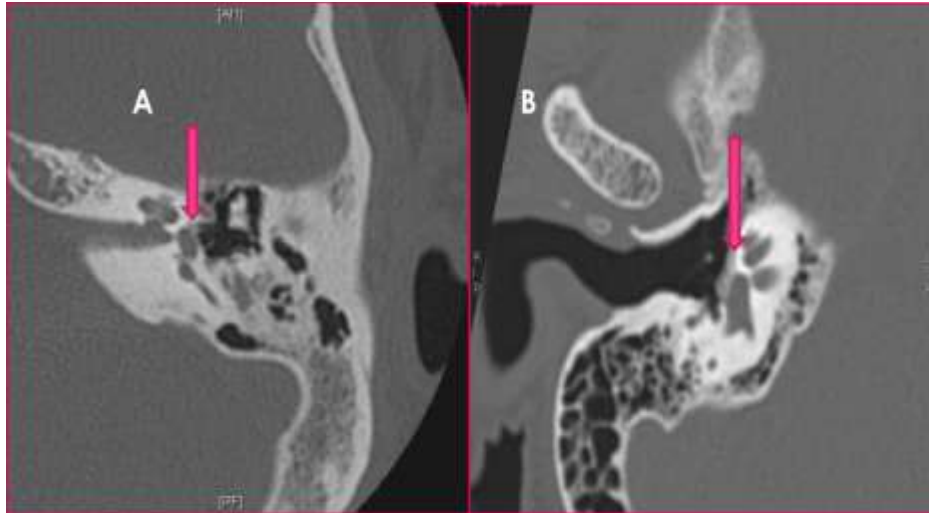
(A and B): CT in axial section showing anterior foci of prestapedial hypodensity of otosclerosis.
